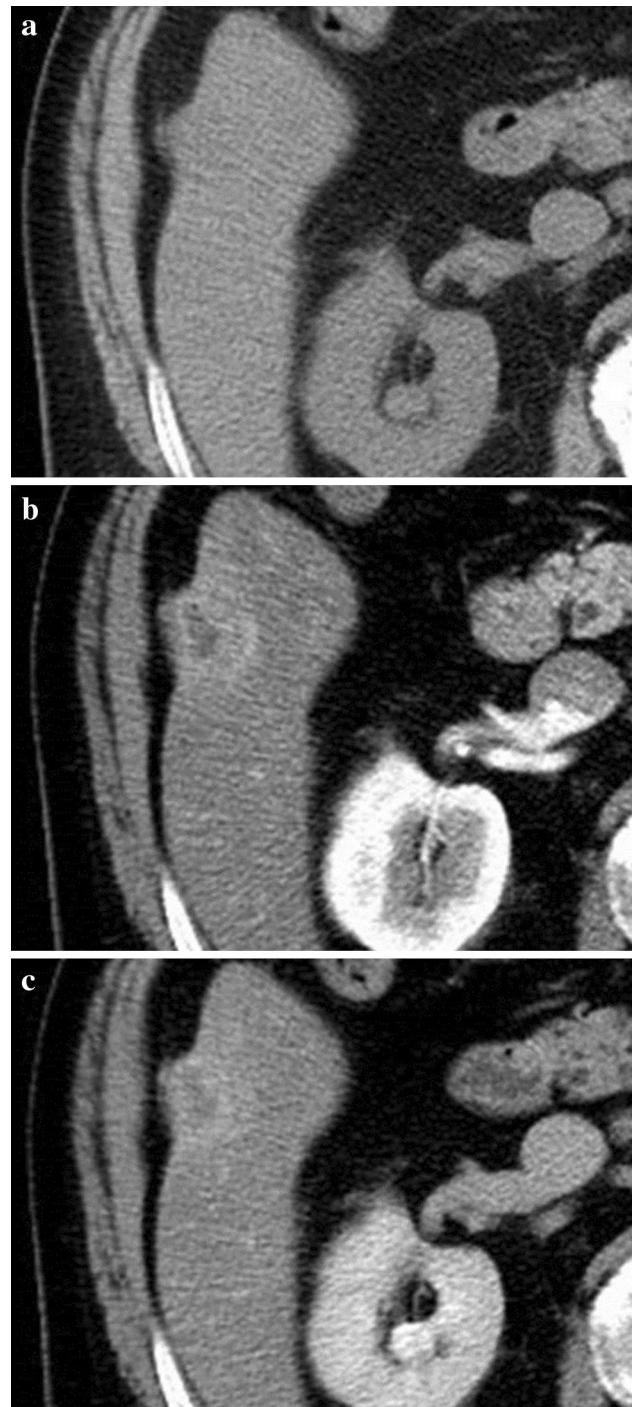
Abdominal CT images. a Precontrast image showing a slightly low-density mass which slightly protrudes from the liver surface. b The lesion was peripherally enhanced in the arterial phase, while the central portion was hypoenhanced. c Peripheral enhancement persisted until the delayed phase
